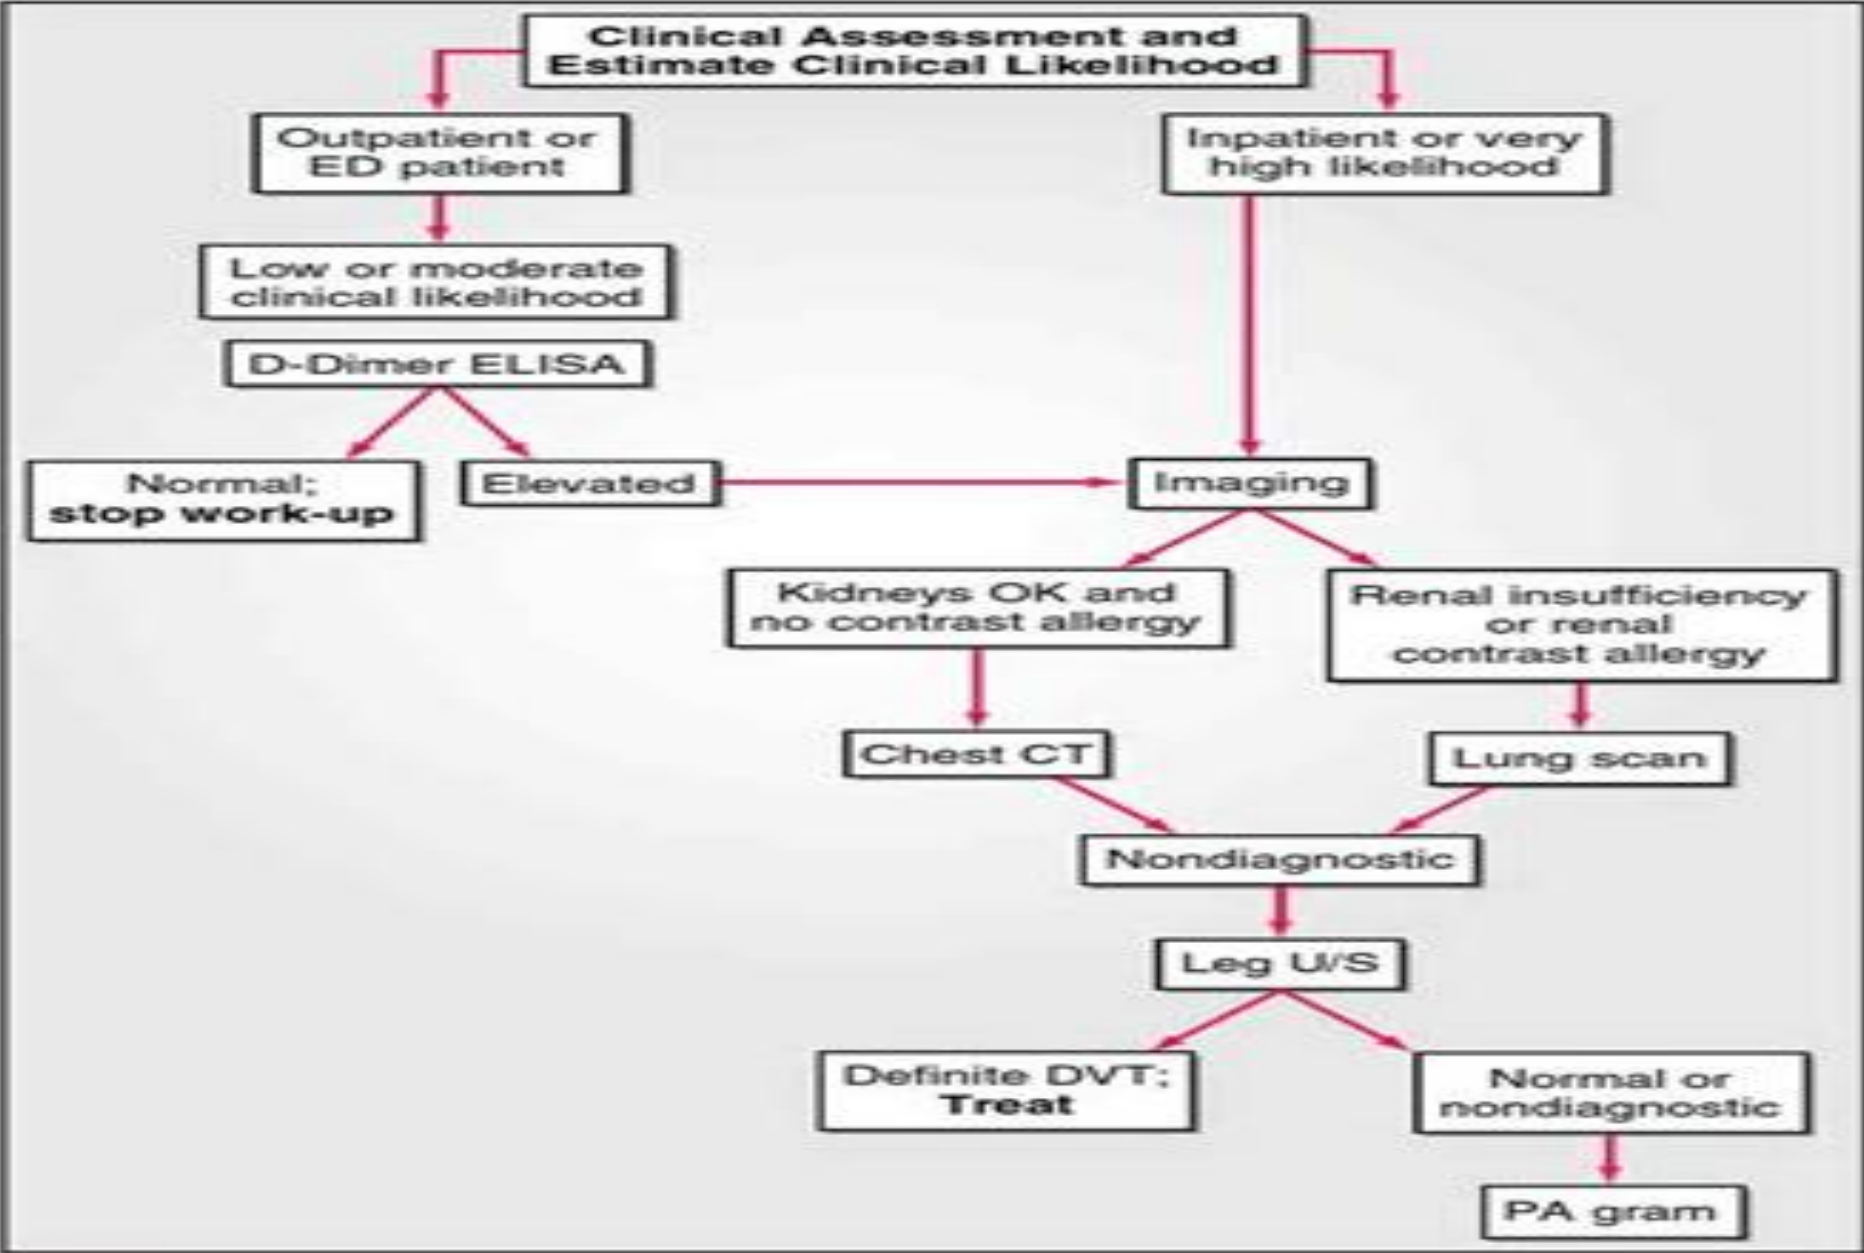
Diagnosis strategy for pulmonary thromboembolism: An integrated diagnostic approach. ED, emergency department; ELISA, enzyme-linked immunosorbent assay; CT, computed tomography; U/S, ultrasound; DVT, deep vein thrombosis; PA gram, pulmonary arteriogram.
